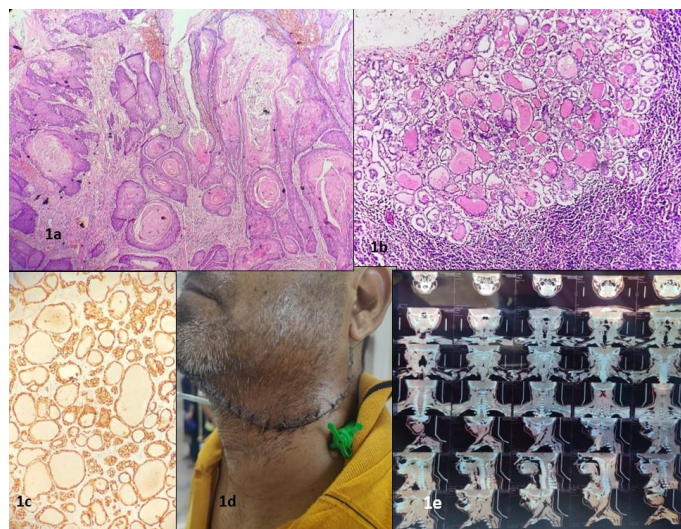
(A) Moderately differentiated squamous cell carcinoma of the tongue (H & E; 100×), (B) Metastatic papillary thyroid carcinoma in a lymph node (H & E; 200×), (C) HBME1-positive tumor cells (IHC; 100×), (D) Post-hemiglossectomy with modified radical neck dissection, showing no palpable thyroid mass, and (E) CT scan showing multiple hypodense nodules in the left lobe of the thyroid, consistent with colloid nodules.
